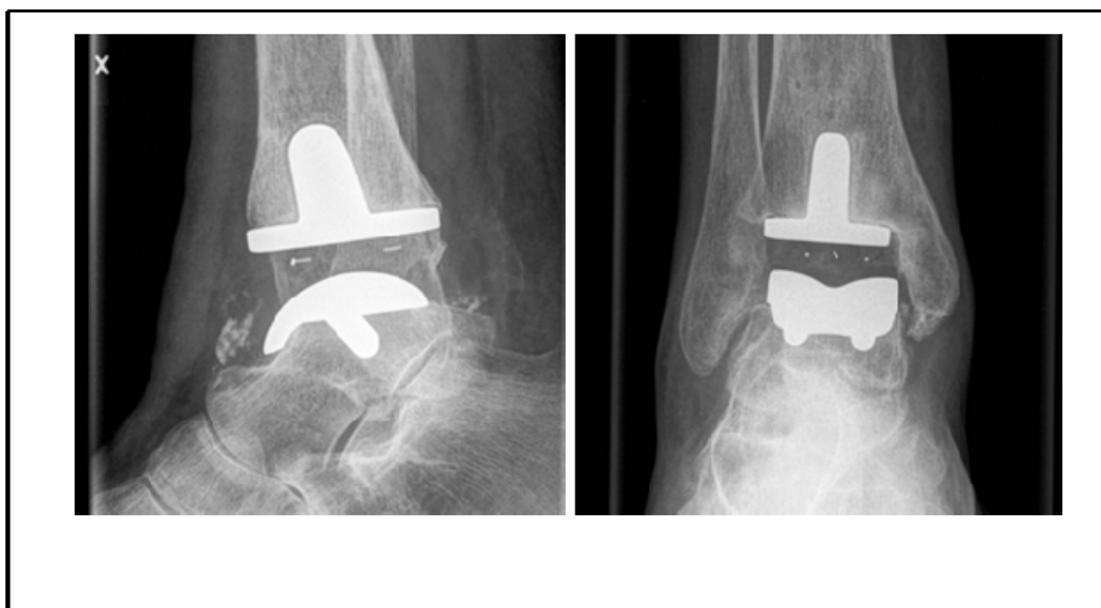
X-ray of the Rebalance-ankle. Lateral view (left), ap-view (right).
